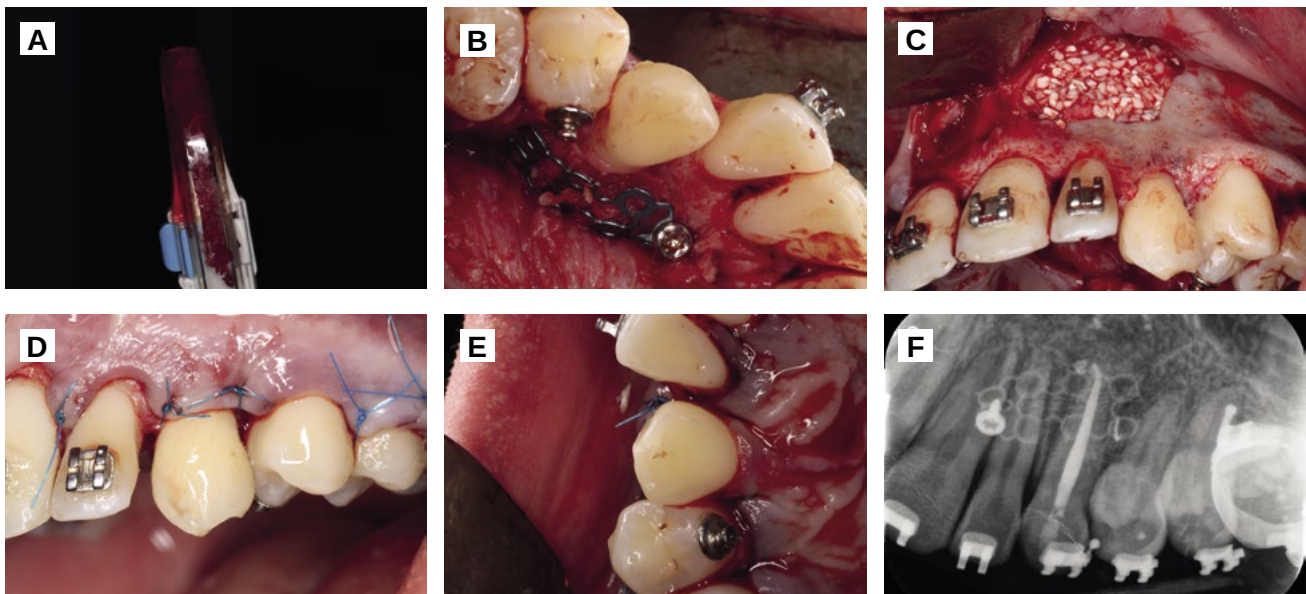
A. Autologous bone of the mandibular ramus. B. Placement of palatal mesh and filling of the defect with autologous bone. C. Vestibular gap filling with xenograft. D. Vestibular view of the sutured flap. E. Occlusal view. F. Post endodontic periapical radiography after 2 weeks of the surgery.
